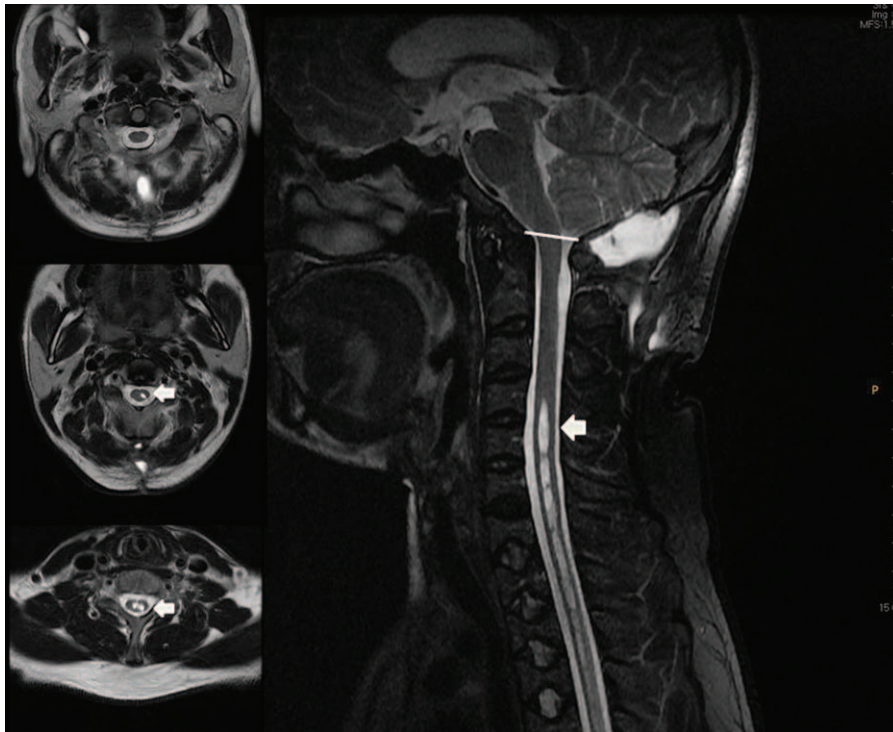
Follow-up magnetic resonance imaging, 2 months postdecompression of the foramen magnum, showing partial improvement of the extensive syringomyelia in cervicothoracic spinal cord.
